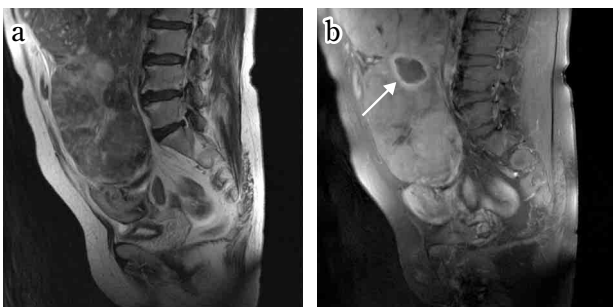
T2-weighted MR images showing a huge pelvic heterogeneous mass (a) and T1-weighted fat-suppressed gadolinium-enhanced MR images showing cystic changes (arrow) associated with hemorrhage or necrosis (b).
